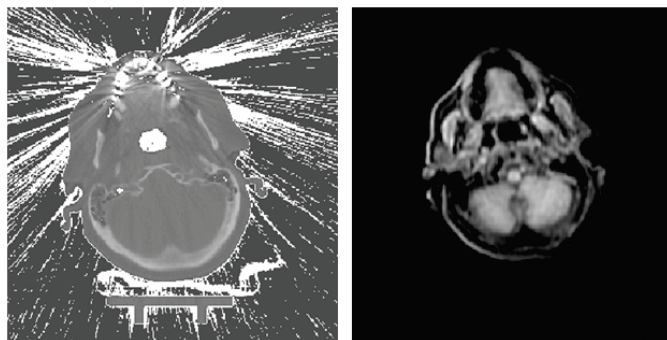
Thresholding mask on CT image and corresponding MR image
